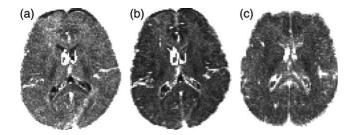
χ_p^2 maps of the three DT schemes using standard DT-MRI, scaled as in Figs. 6b,g. The same slice of one subject is shown for schemes A (a) and B (b); a homologous slice of a different subject is shown for scheme C (c). Phase-encoding direction: left-right (A and B), anterior-posterior (C).
